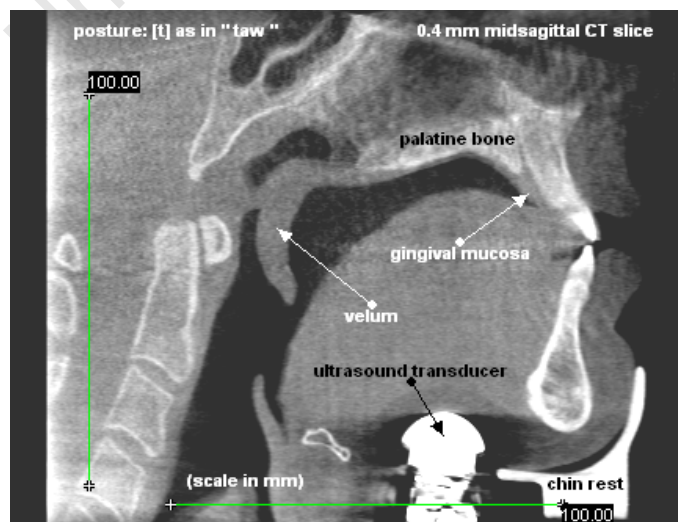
CT image of the human tongue [33]
